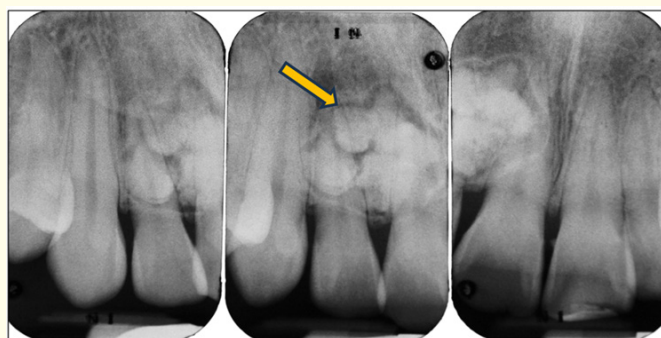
Radiographs of the mass show it to be comprised of numerous calcified globular constructions, sometimes forming into tooth-like structures (arrow).
